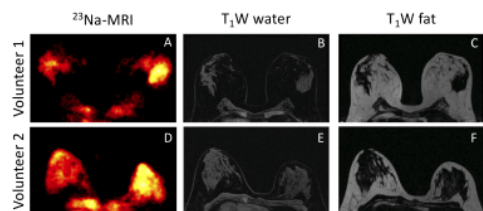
^{23}Na -MRI (A, D) and T_1 -weighted water (B,E) and fat images (C,F).
